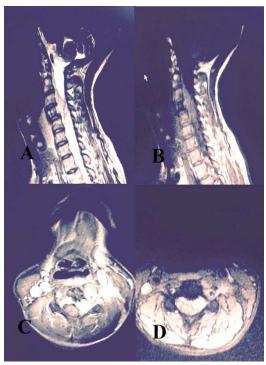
A, B,C,D - Mass lesion, compressing the spinal cord by filling the posterior C3-C4-C5 epidural space, that is hyperintense on sagittal T2-weighted MRI, hypointense on sagittal T1-weighted MRI
